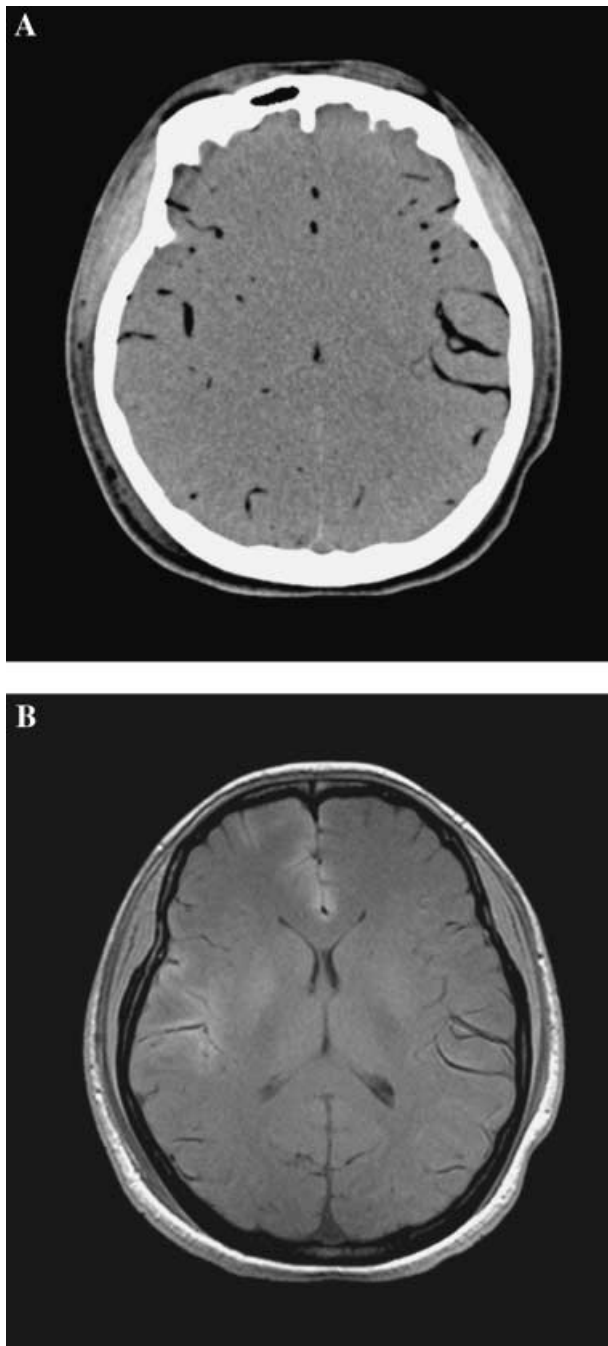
CT and MR images of the CVH male (a) and female (b) head.
